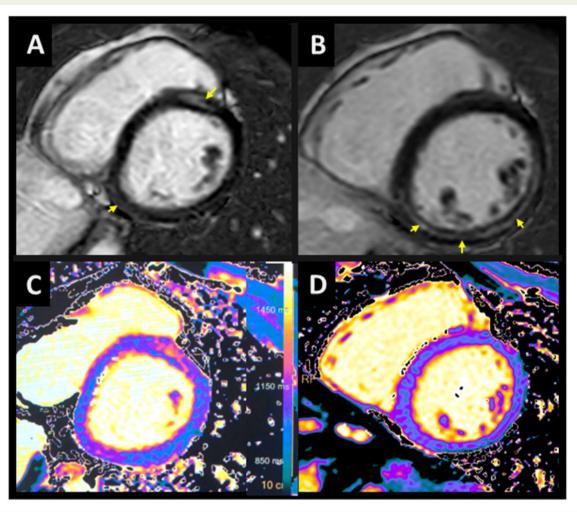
Figure I Representative example of cardiac magnetic resonance imaging in patient number 7 demonstrating late gadolinium enhancement involving the mid-wall of the basal antero-septal and inferior segments (*A*), and of the mid-ventricular inferior and infero-lateral segments (*B*). A corresponding myocardial injury in native T1 mapping is presented (*C* and *D*).
